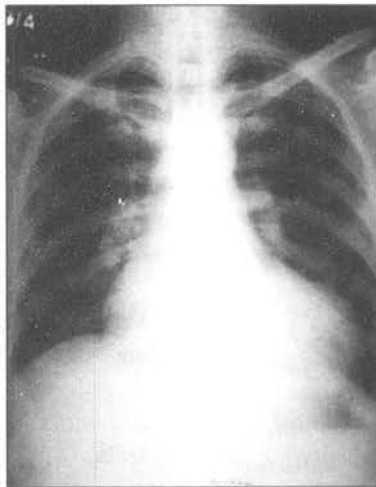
X-ray heart (PA view). A case of valvular heart disease (aortic with left ventricular enlargement (boot-shaped heart))
